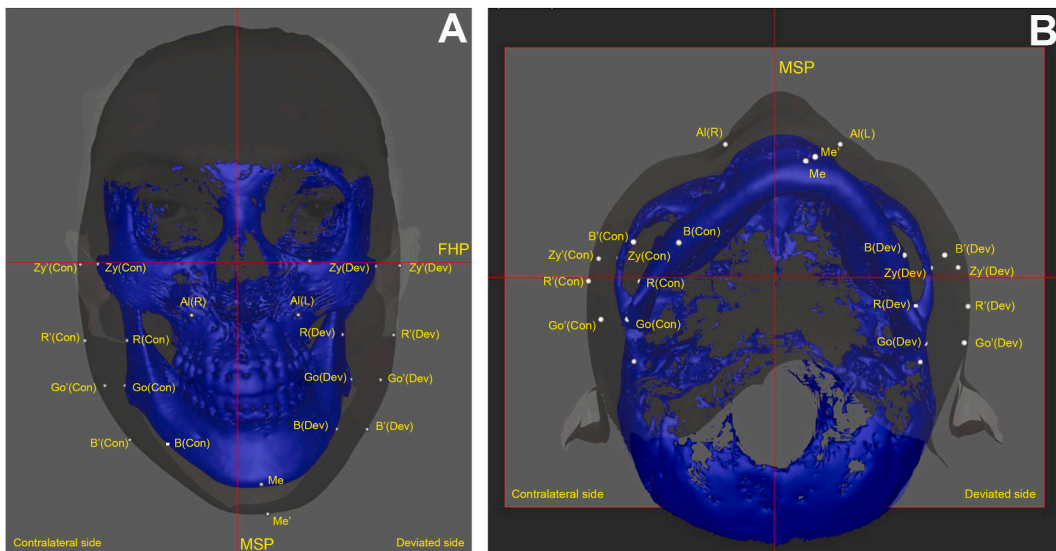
The face was divided into two sides based on the menton deviation: deviated (Dev) and contralateral side (Con). All anatomical landmarks were located on CBCT imaging in the 3D Morpheus program. Hard tissue landmarks: Zy, zygonion; R, ramus of mandible; Go, gonion; B, body of mandible; Me, menton. Soft tissue landmarks: Zy', soft tissue zygonion; R', soft tissue at ramus level; Go', soft tissue at gonion level; B', soft tissue at body level; Me', soft tissue menton; Al(R), right alare; Al(L), left alare. Reference planes: MSP, midsagittal plane; FHP, Frankfort horizontal plane. In frontal view (A) and in transverse view (B).
